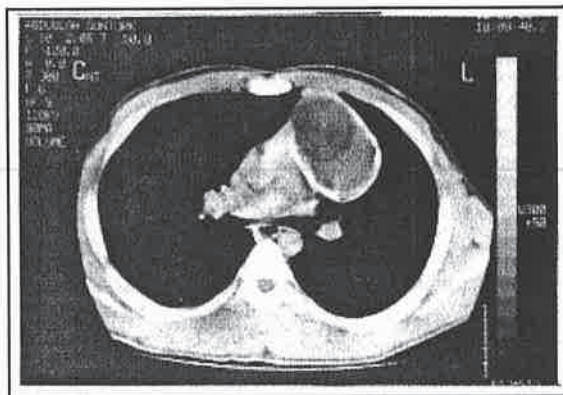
CT Image of "Mature Cystic Teratoma"
